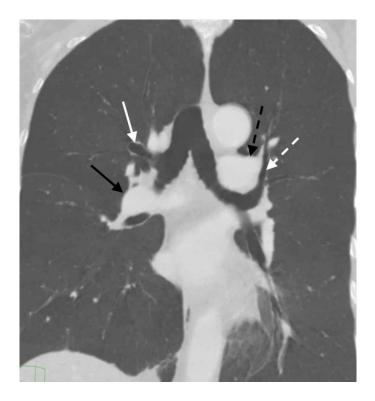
CT coronal MIP images shows Normal pulmonary sideness of broncho -pulmonary anatomy, $\{S,_,_\}$: (1) Hyparterial position of left main bronchus and eparterial position of right main bronchus(black arrow: right main pulmonary artery; black dashed arrow: left main pulmonary artery). (2) Proximal take-off of the right upper lobe bronchus (white arrow) and distal take-off of the left upper lobe bronchus (white dashed arrow)
